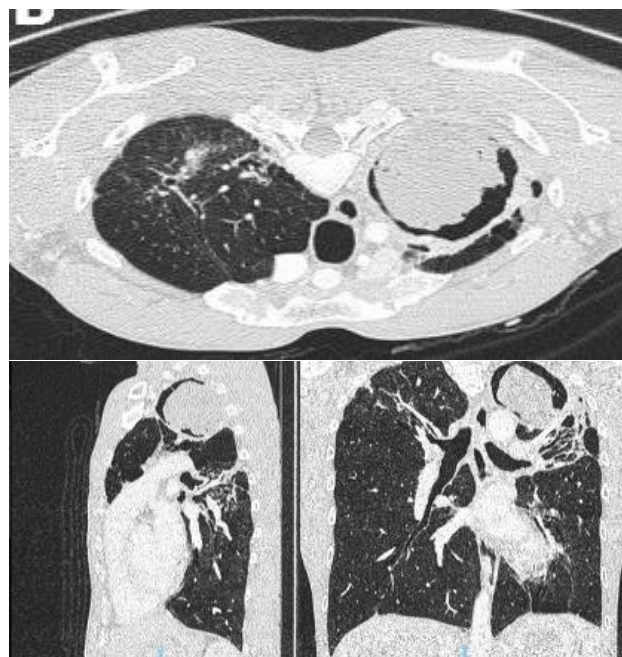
Contrast-enhanced chest CT scan, suggestive of inactive pulmonary TB with a fungus ball in the left lung (November 2<sup>nd</sup>, 2023)
